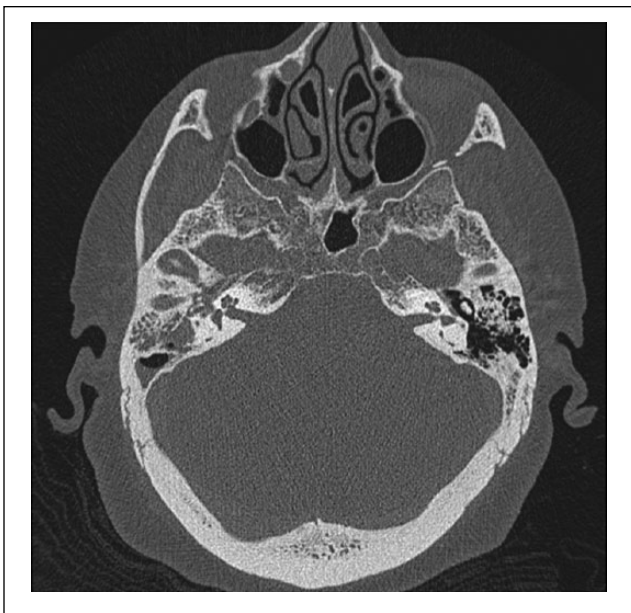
Contrasted computed tomographic axial image of temporal bones, showing an opacified right mastoid and middle ear cavity with ossicles in place.
